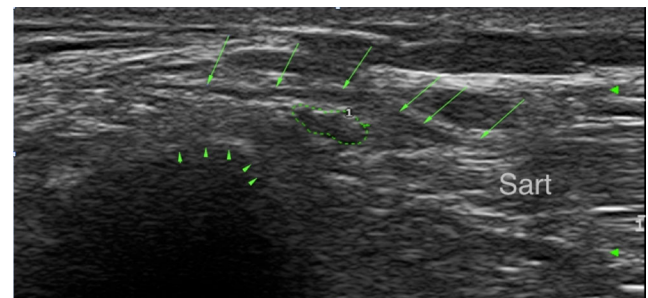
Axial ultrasound scan of the right thigh, showing a slightly thickened lateral femoral cutaneous nerve (LFCN; encircled) close to the distal aspect of the anterior superior iliac spine (arrowheads) with partial depiction of the inguinal ligament (arrows), showing a hypoechoic thickening of the ligament close to the LFCN. (Sart) sartorius muscle
